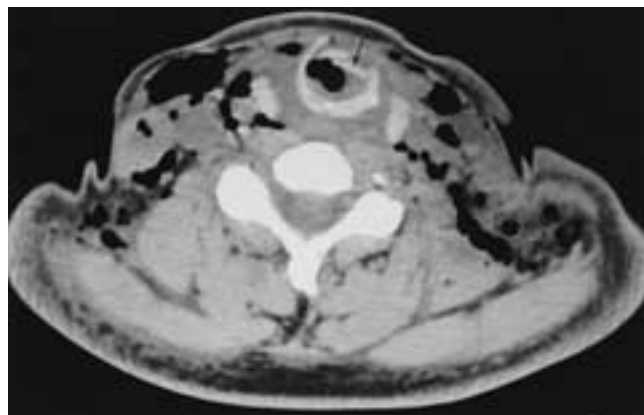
Axial CT shows fracture of the cricoid, with posterior positioning of the fragments (arrow) into the airway.
